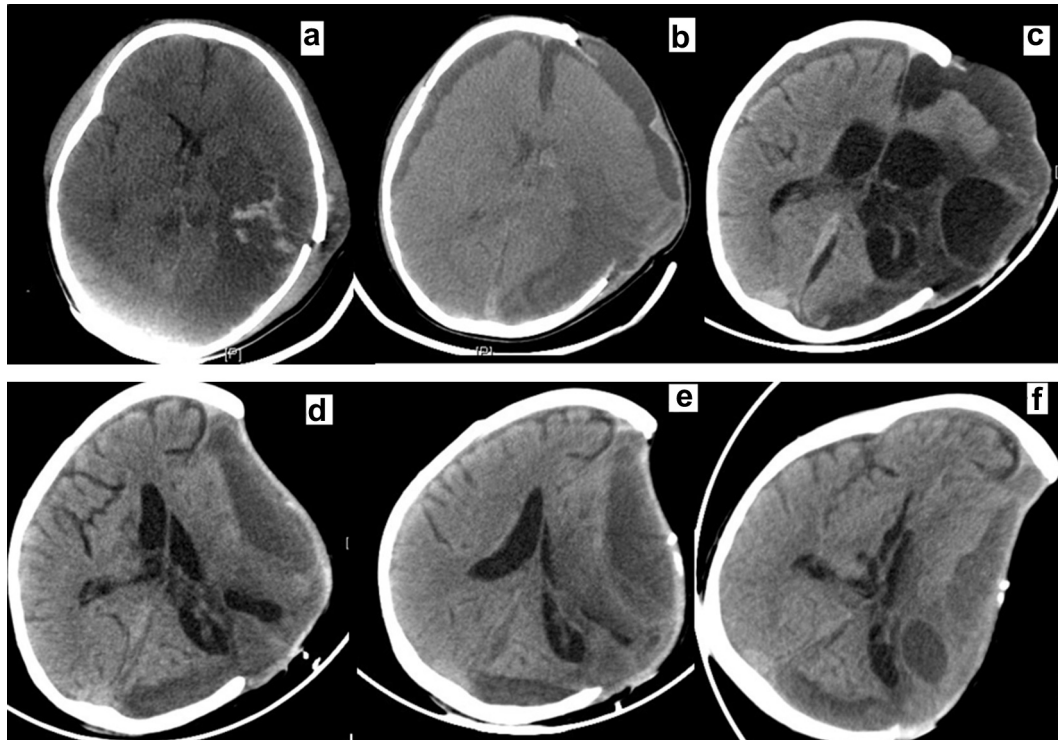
(a–c) Plain CT head of a 4-year-old male child who sustained Road traffic injuries, showing evidence of contusion with overlying parietal bone fracture (a), and was subjected to left fronto-temporo-parietal DC (b), developed flap bulge and PTH with Subdural hygroma on POD 35 (c). Plain CT head of the same patient following TP shunt at day 3 post shunt (d), 10 days post shunt (e) and 32 days post shunt (f) showing progressive decrease in ventricular size and flap bulge with resolution of subdural hygroma.
